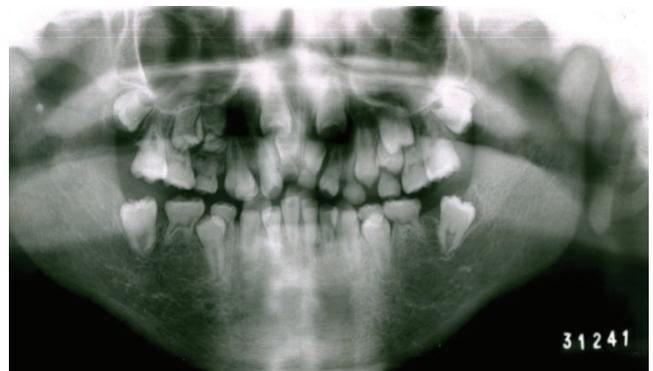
Orthopantomographic radiograph: dental root shortening of all permanent teeth.
